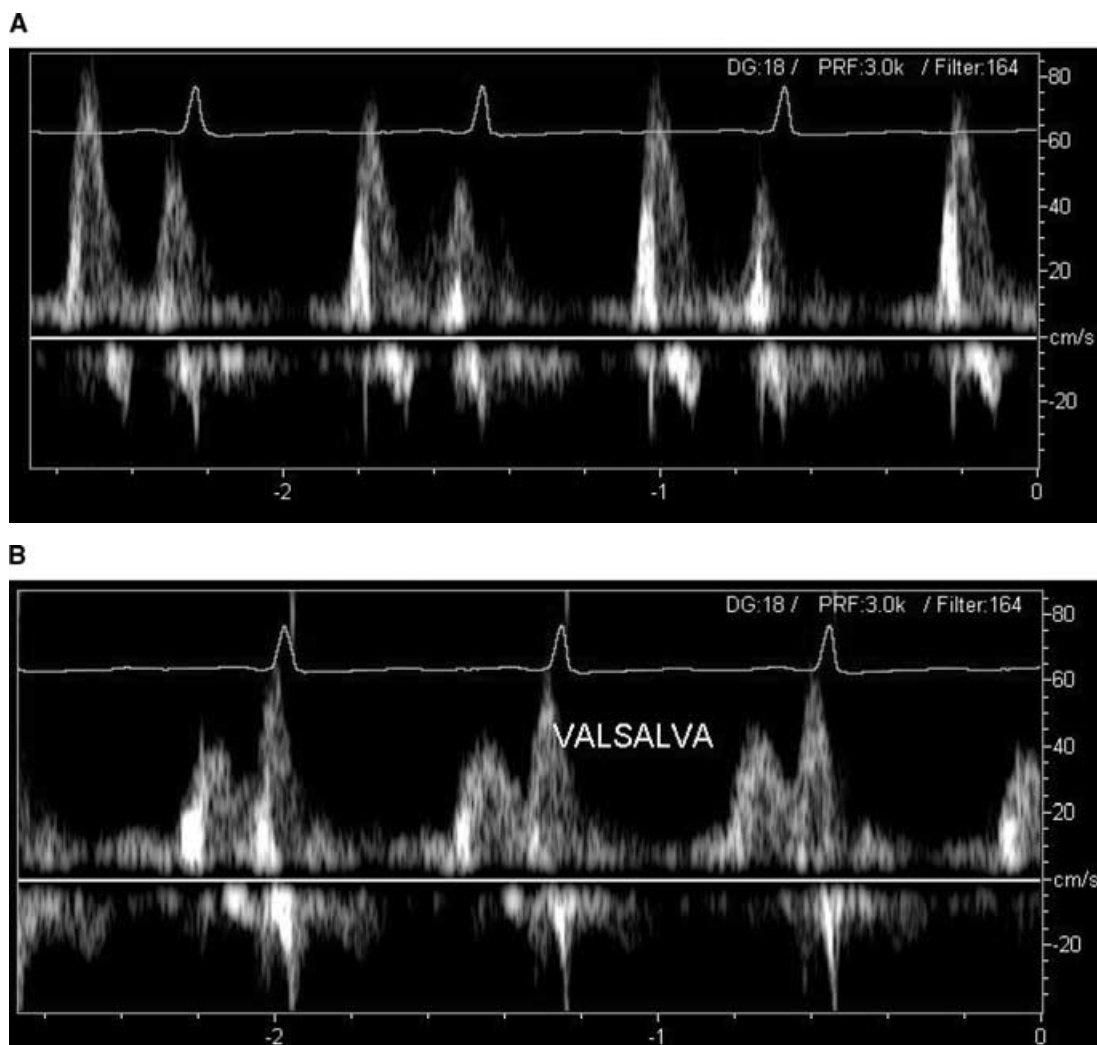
A middle-aged male with long-standing hypertension and resultant systolic dysfunction presented with heart failure symptoms. Apically obtained mitral inflow pulsed wave Doppler patterns were then obtained. A. The mitral inflow pattern appears “normal,” but (B) repeat mitral inflow patterns measured during the Valsalva maneuver become that of abnormal relaxation. This is consistent with “pseudonormal” mitral filling, secondary to abnormal relaxation with elevated left atrial filling pressures.
